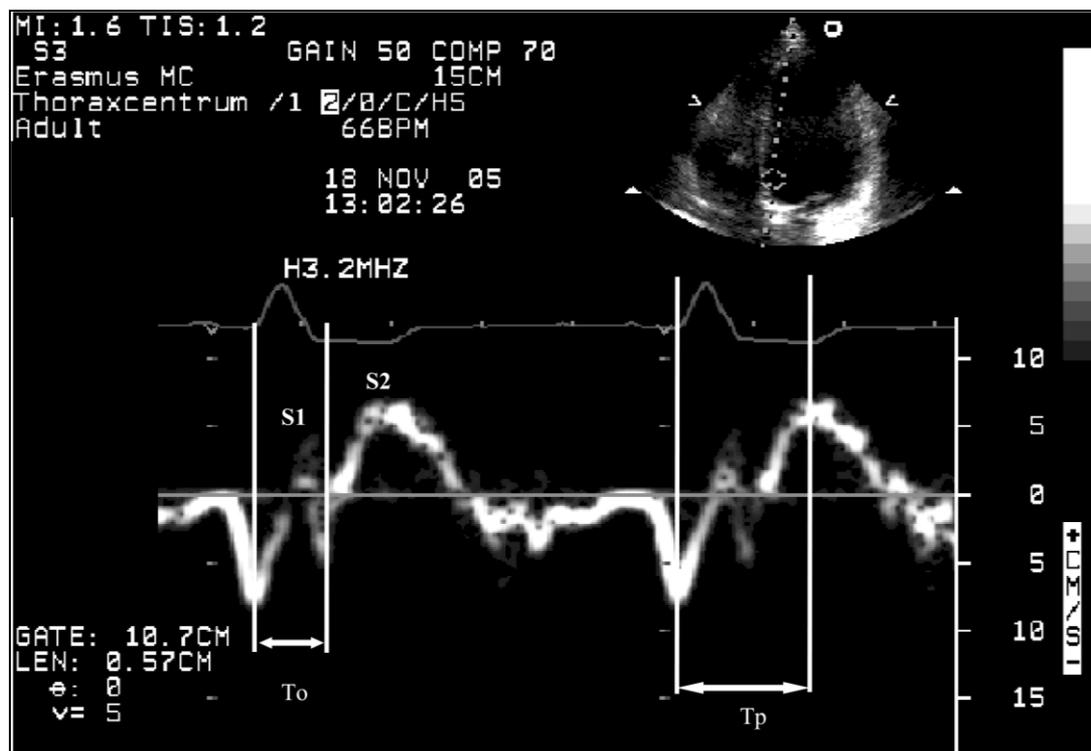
Measurement of time-to-onset and time-to-peak on tissue Doppler imaging: S1 and S2 are the myocardial velocity waves during isovolumic contraction phase and during systole respectively, two headed arrow between the two white lines represent time interval from beginning of QRS to onset (T_o) and to peak of S2 (T_p).
